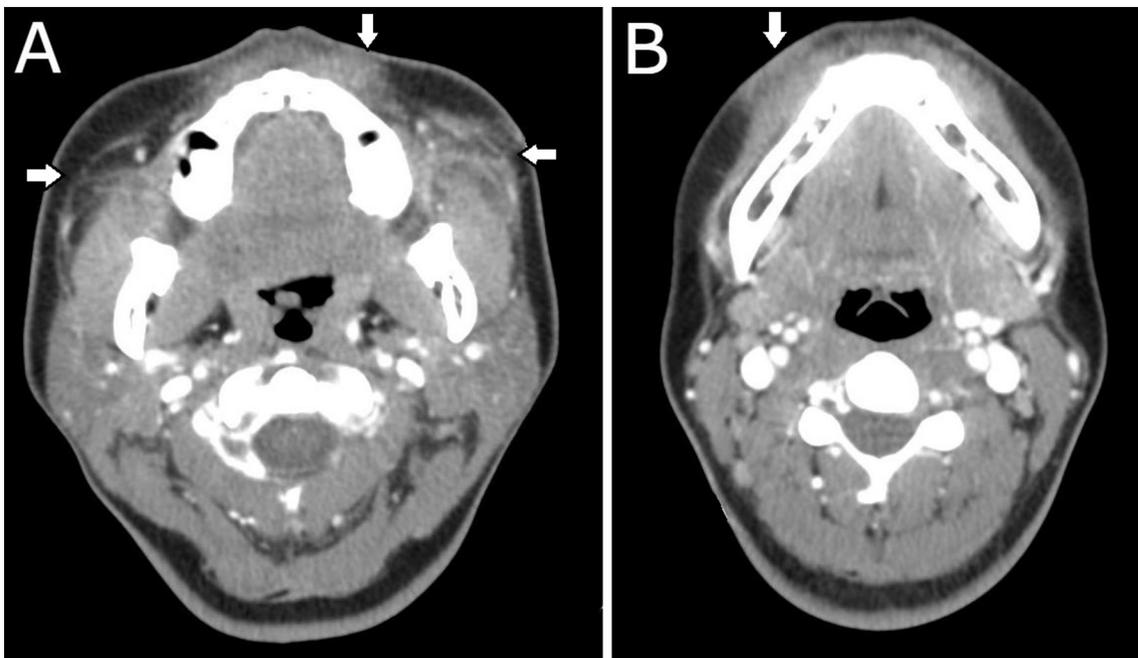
A) Axial CT at the level of the upper face demonstrates infiltrating soft tissue inflammatory changes without mass effect involving the subcutaneous adipose layer along the left upper lip, with involvement of the left maxillary pre-antral fat. There is no cystic component and no discrete collections. There are also bilateral, left-greater-than-right, inflammatory changes of the superficial musculoaponeurotic system (SMAS) of the face, involving the bilateral buccal spaces, anterior to the master muscles. B) Axial section at the level of the body of the mandible demonstrates inflammatory changes involving the superficial fat and SMAS of the right chin, adjacent to the parasymphysis of the right mandible.
